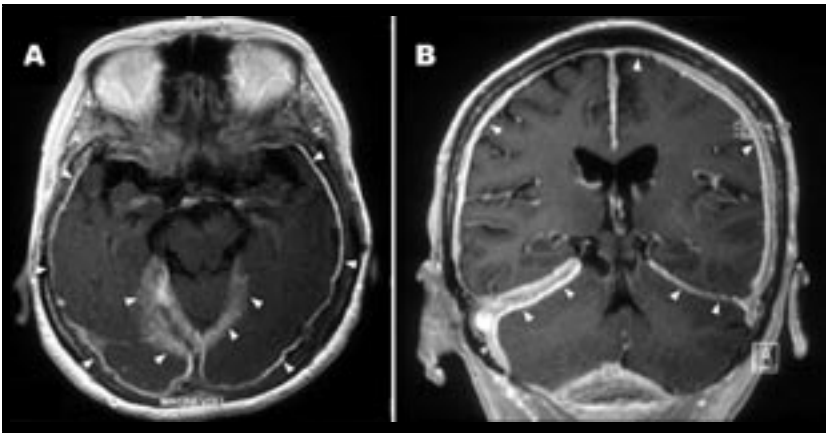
Post-gadolinium enhanced axial (A) and coronal (B) MR images showed diffusely prominent dural enhancement at both convexities and along the tentorial cerebelli (arrowheads), compatible with pachymeningitis.
